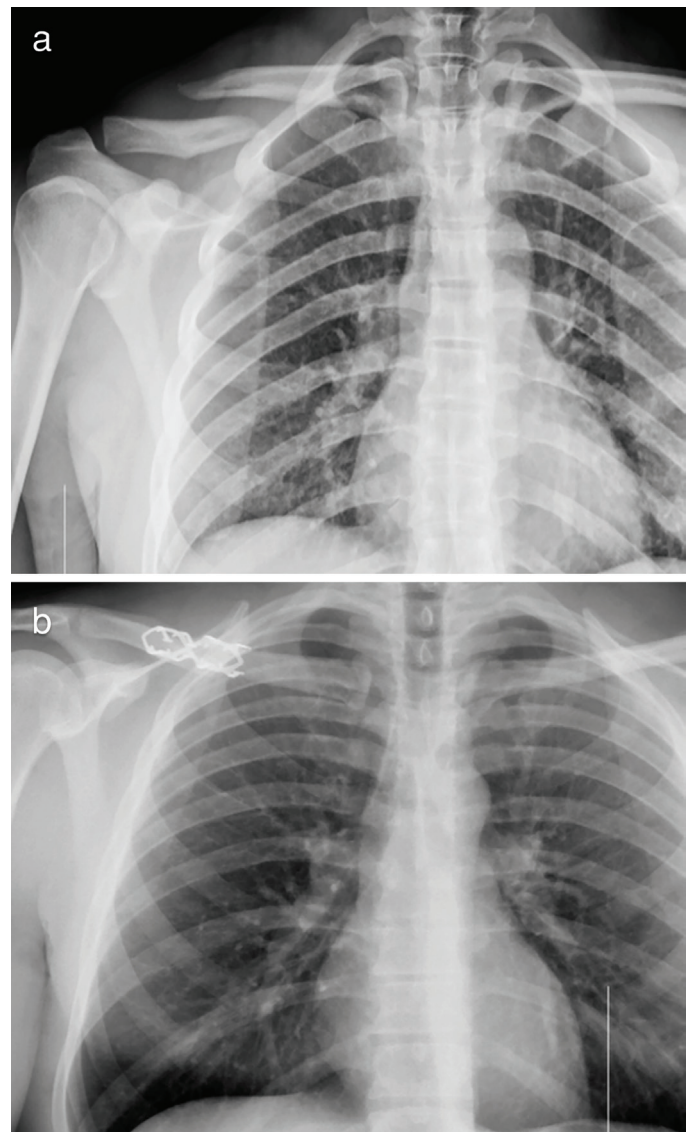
a) Preoperative postero-anterior chest radiography. b) Postoperative postero-anterior chest radiography
